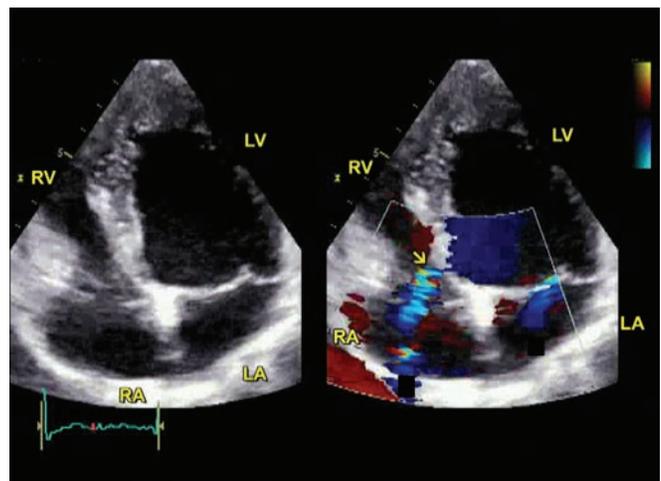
Abnormal color Doppler finding, apical 4-chamber view. (LA: Left atrium; LV: Left ventricle; RA: Right atrium; RV: Right ventricle).
